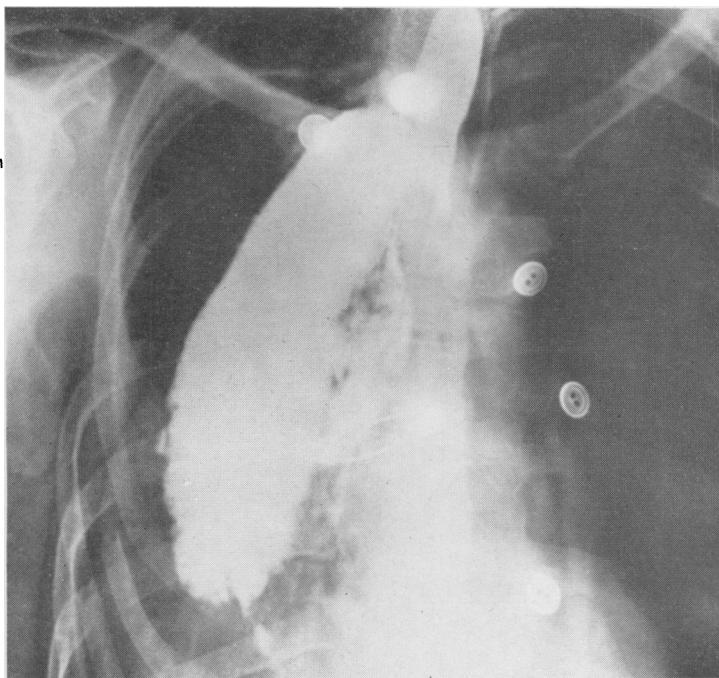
X-ray of palliative oesophago-gastrostomy for carcinoma shown in Fig. 1.
